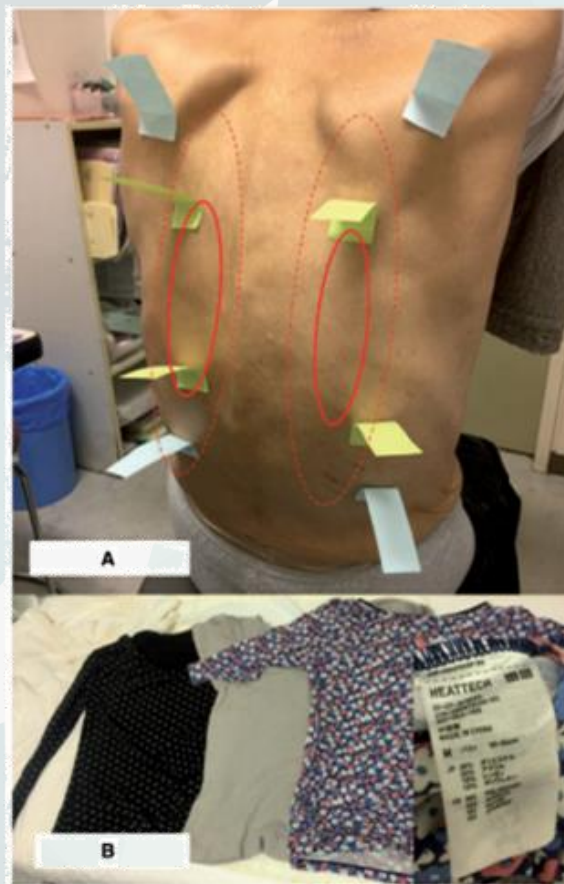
(A) One day after the completion of MRI of the patient's lumbar spine, no obvious dermatological findings were observed. However, a marked hyperesthesia-like area similar in appearance to a sunburn was observed, particularly in the centre of the ellipse. (B) The patient wore a total of four layers of novel underwear with Japanese heat-retardant technology during her imaging study. She reported wearing these undergarments during a follow-up appointment.
